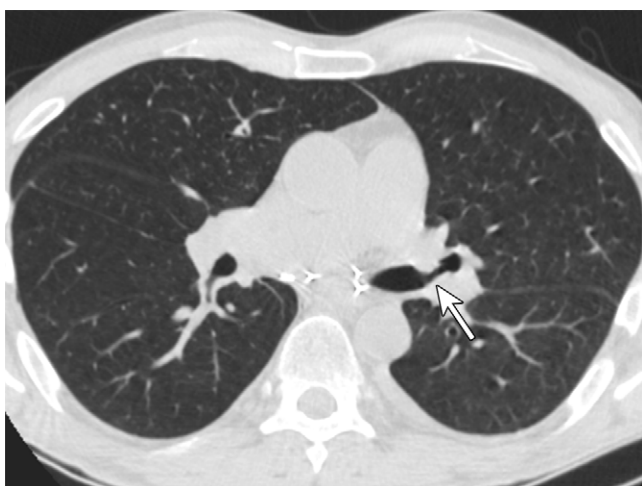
Image in a 52-year-old man with left bronchial stenosis after bilateral lung transplantation for end-stage chronic obstructive pulmonary disease. Axial chest CT lung window image shows focal narrowing of the left mainstem bronchus (arrow) 2 months after lung transplantation.
